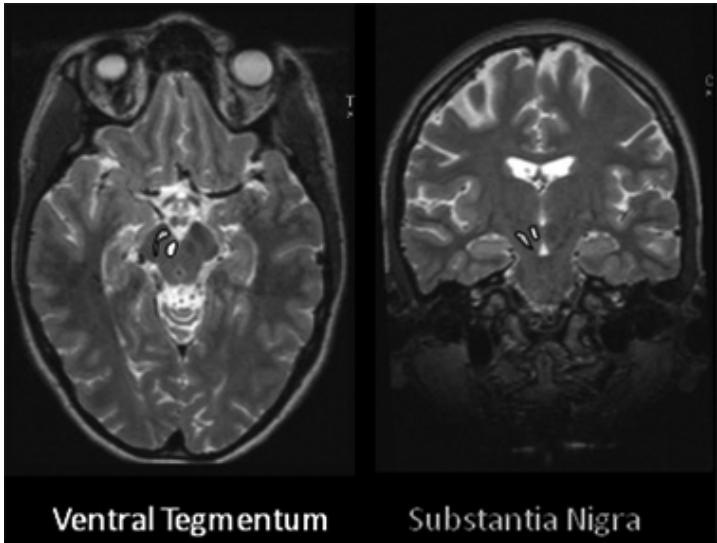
Axial and coronal view of the ventral tegmentum and substantia nigra from a T2-weighted MRI scan
